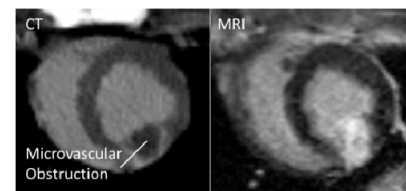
CT and MRI images of the same subject. The CT image shows a large region of MVO whereas the corresponding region of the MR image appears completely bright.
